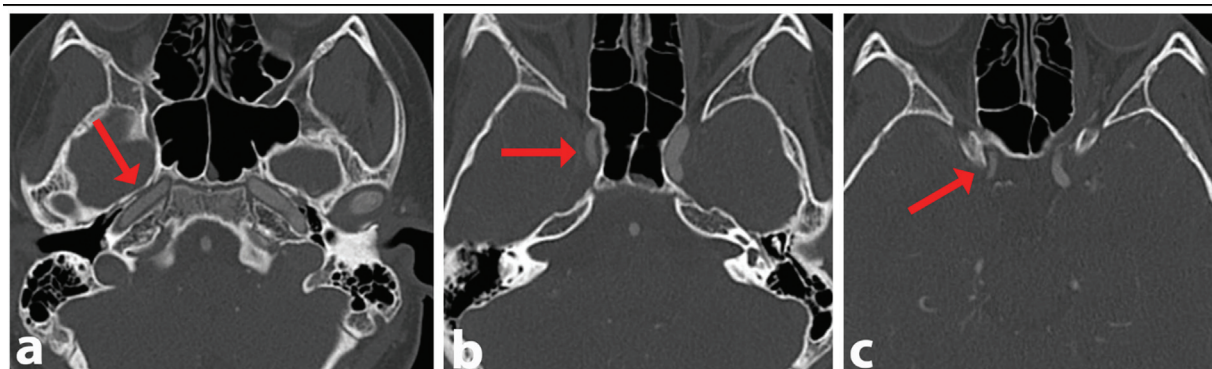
Angio computed tomography scan. All figures are on the axial plane. (a) This image shows a subtle narrowing in the petrous segment of the right internal carotid artery (ICA) (red arrow). (b) Shows a more pronounced narrowing of the right ICA (red arrow). (c) Shows a narrowing in the intracranial portion of the right ICA (red arrow).
